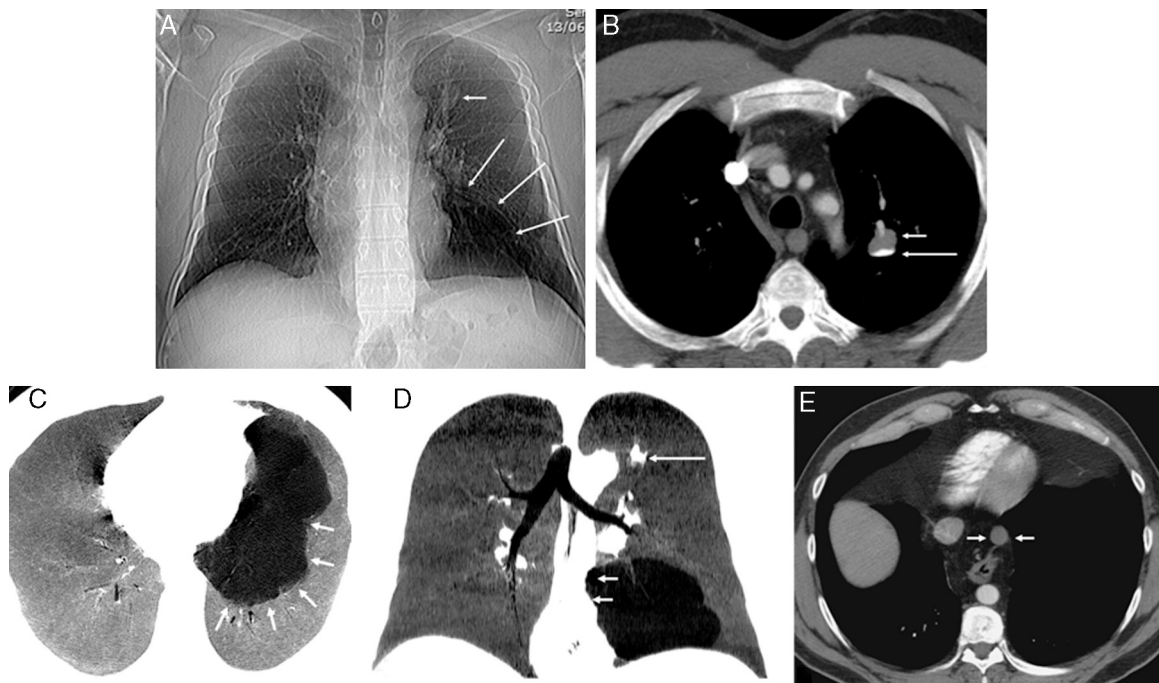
(A) Chest X-ray showing nodular lesions in left upper lobe (LUL) (short arrow) and basal radiopacity with reduced blood perfusion (long arrows). (B) Axial computed tomography (CT) image of chest, confirming the presence of a cystic-type lesion in the left upper lobe, with typical fluid–fluid level. The supernatant (short arrow) has a density similar to water, while the density of the fluid in the lower part (long arrow) is calcific (calcium milk). (C) MinIP (minimum intensity axial projection) CT image showing a well-defined multicystic lesion (arrows), suggestive of malformation, in the left lower lobe basal segments, not communicating with the airway. (D) MinIP coronal reconstruction showing a mild mass effect on the mediastinum towards the right side (short arrows). Note the nodular lesion in the LUL (long arrow). (E) Axial CT image showing a cystic lesion in the posterior mediastinum, adjacent to the anterior thoracic esophageal margin (arrows).
